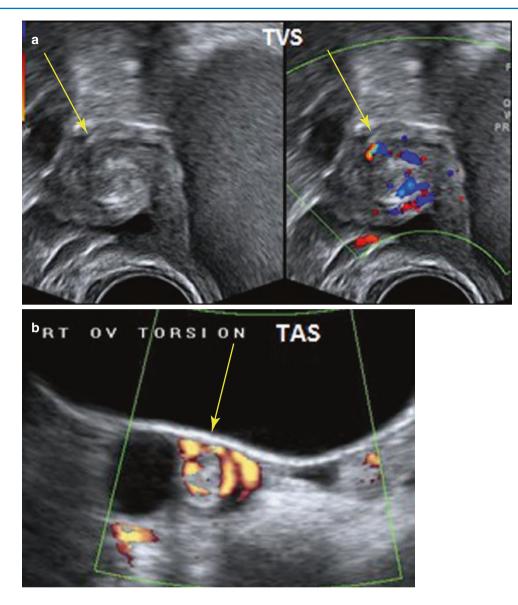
Whirlpool sign (*arrows*). (a) TVS – on greyscale and colour Doppler and (b) TAS – with power Doppler. This is a real-time finding. On a frozen image, it is seen as a cross section of the pedicle with multiple concentric stripes of tissue on greyscale and as circularly placed vessels on Doppler
